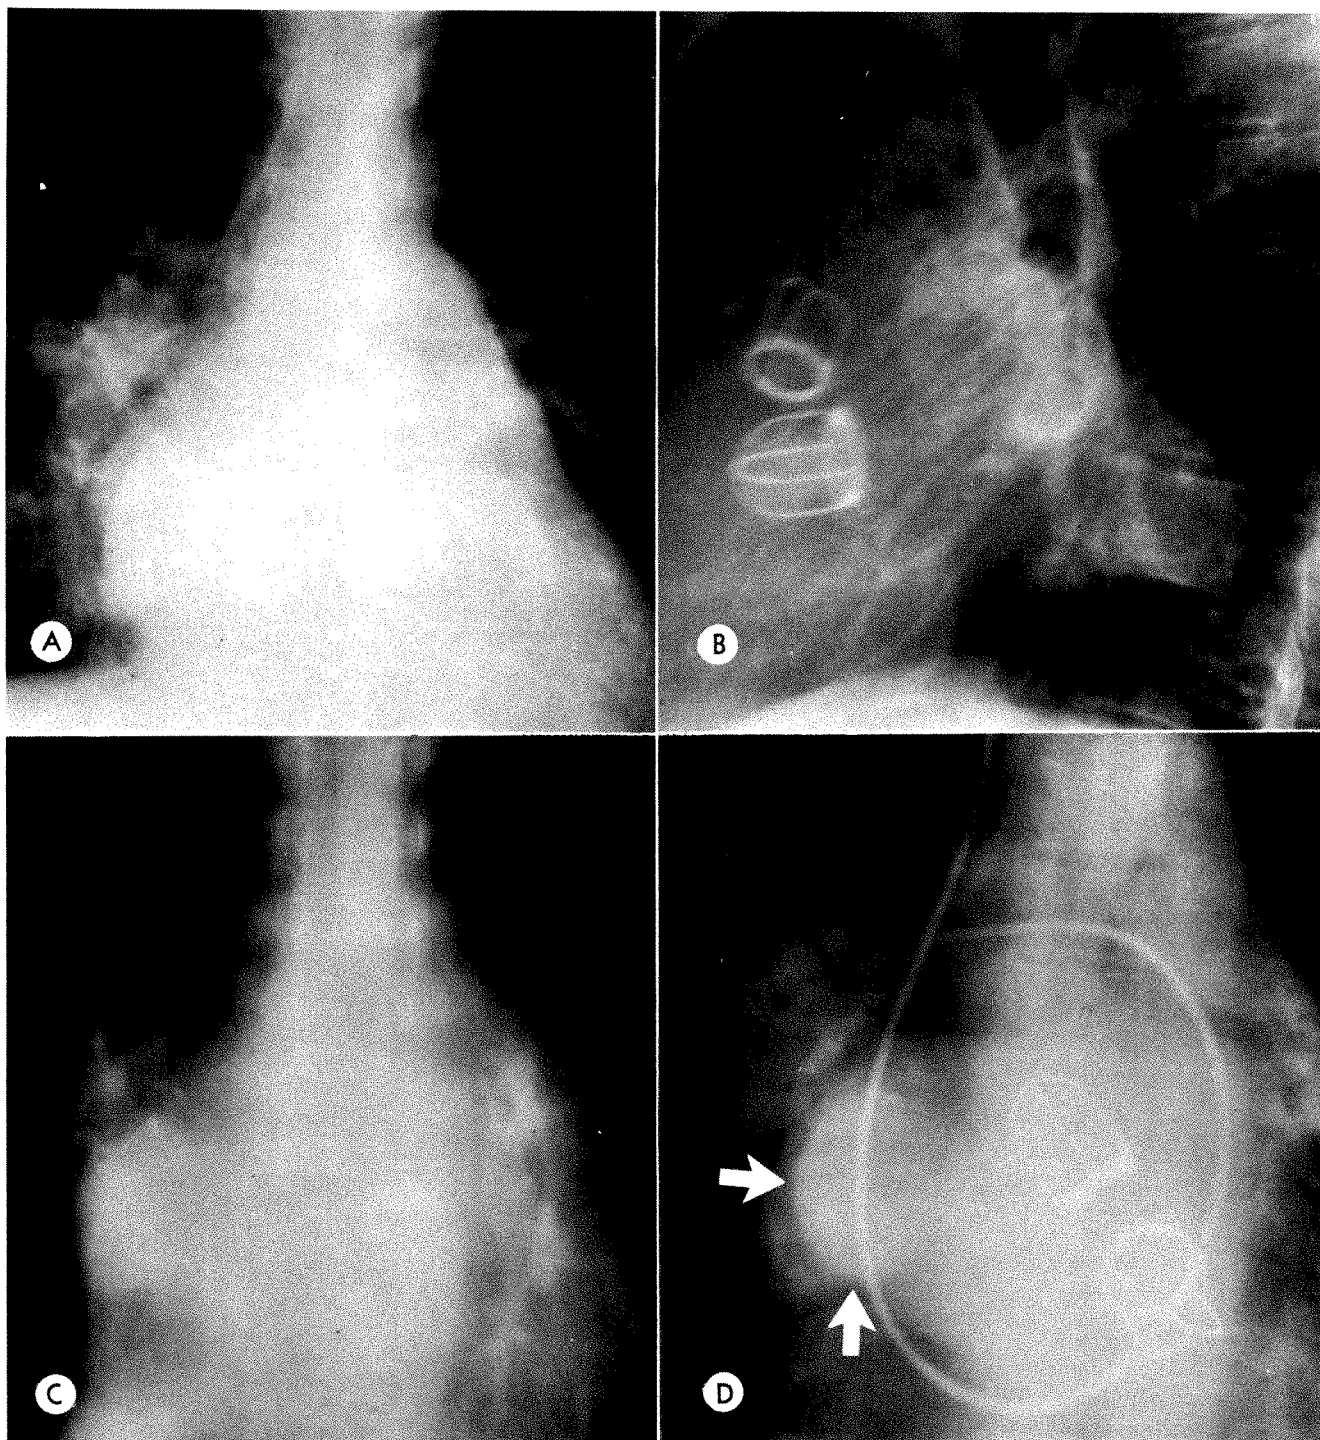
Case 4. *A and B*. Chest radiographs showing enlarged heart and dilated pulmonary veins. "Mass" is noted posterior to right side of heart. *C*. *AP* tomogram 2 months later delineating oval-shaped density posterior to right side of heart. *D*. Pulmonary angiogram revealing markedly dilated right upper lobe pulmonary vein at its junction with left atrium (arrows).
